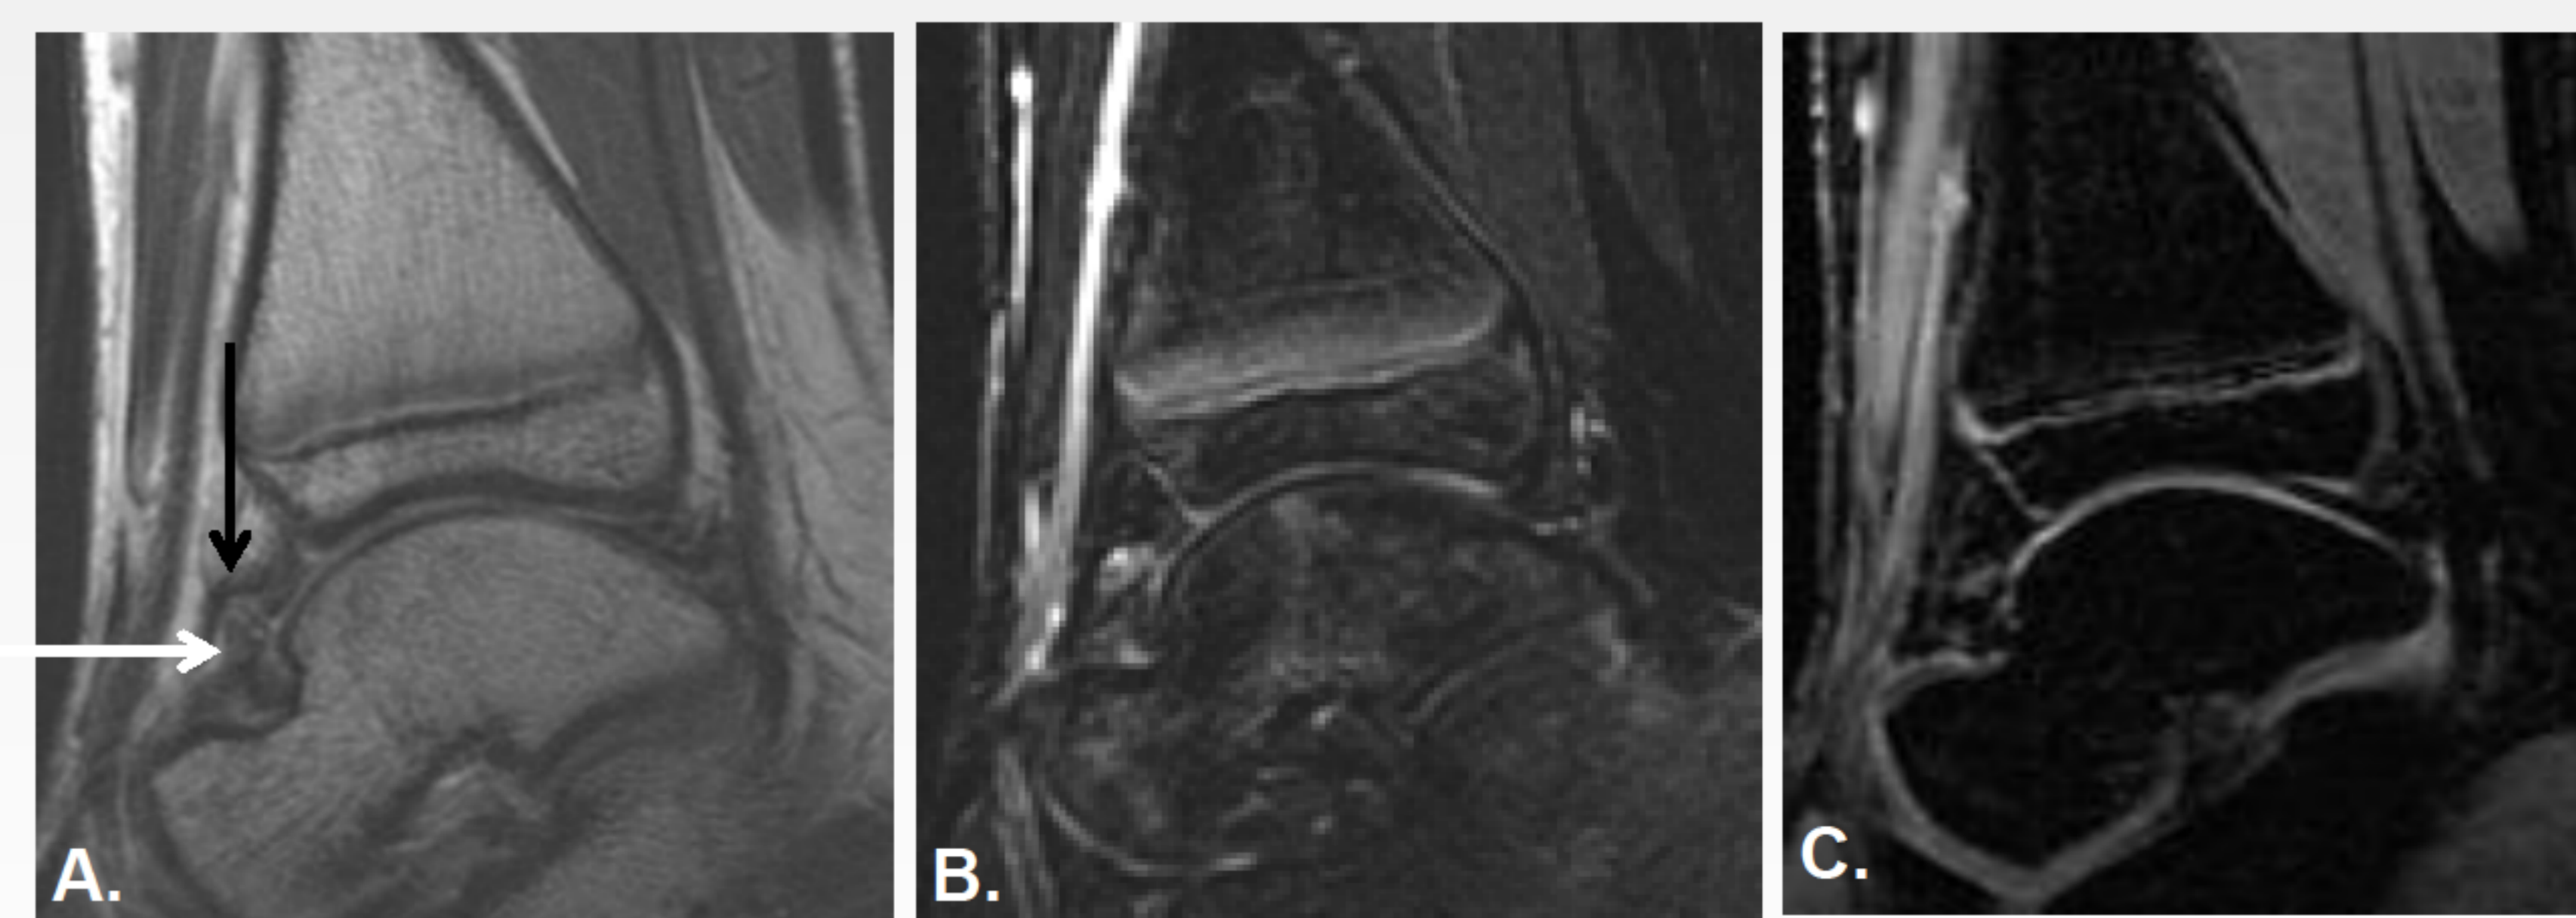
Fifteen-year-old boy with severe hemophilia A. Full protocol sagittal proton density [PD] (A), T2 (B) and gradient-echo [GRE] (C) MR images of his right ankle show mild synovial hypertrophy (=1), mild hemosiderin deposition (=1), no joint effusion/hemarthrosis (=0) or osteochondral damage (=0, 0, 0). Final IPSG MRI score, 2 (ST, 2; OC, 0). Because the PD sequence (A) does not produce susceptibility artifacts conversely to GRE (C) it enables better distinction between synovium (in grey, white arrow) and hemosiderin deposition (in black, black arrow) than the GRE sequence.
